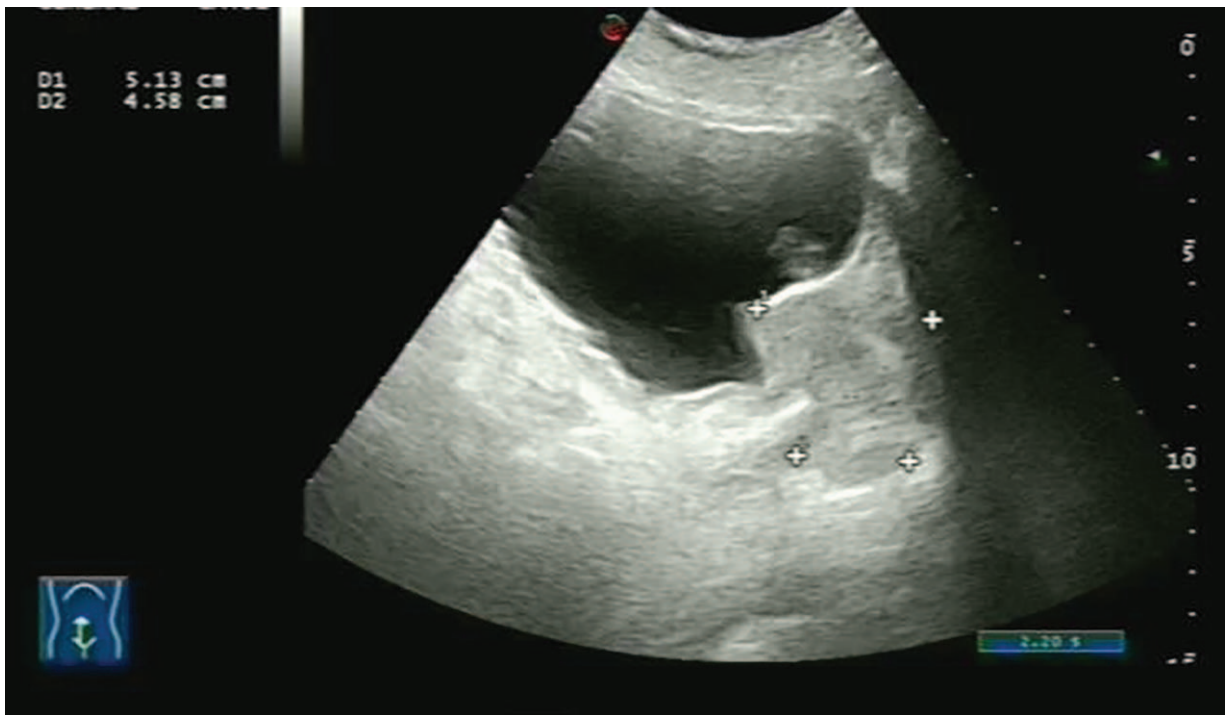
Abdominal ultrasonography image showing a mildly enlarged prostate (46mL) with residual urine of about 168 mL.
